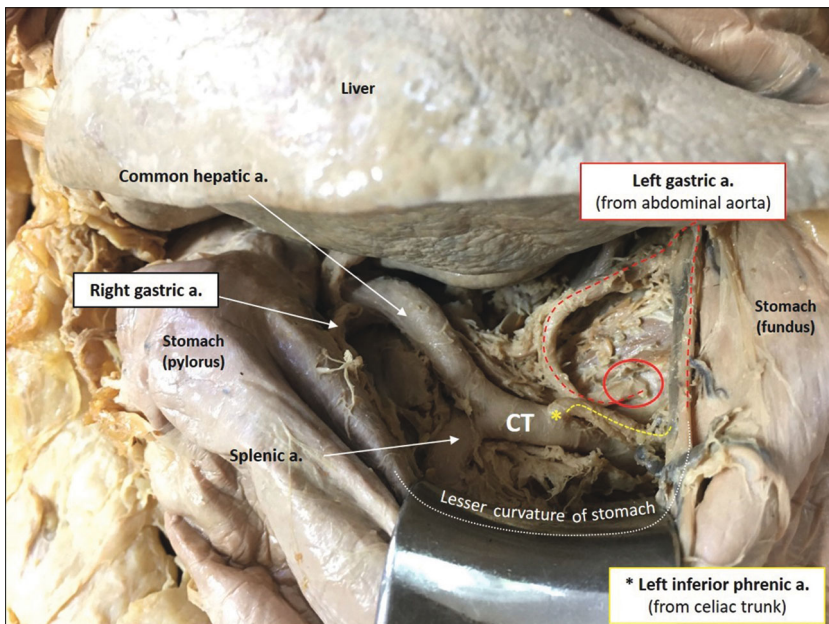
Variable origin and course of the left inferior phrenic artery and left gastric artery. CT- celiac trunk.
